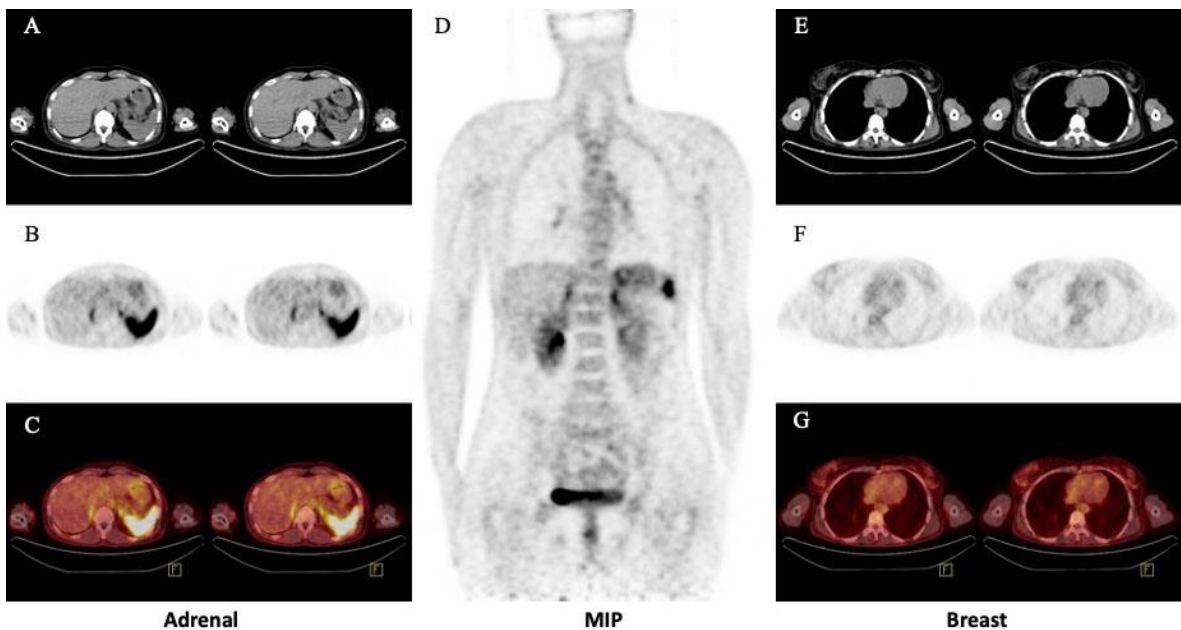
[⁶⁸Ga] Ga-Pentixafor PET/CT. depicting slices of adrenals and breasts normal uptake
